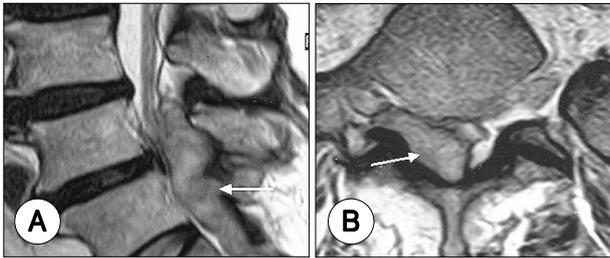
A : Preoperative sagittal T1-weighted magnetic resonance image shows a low signal intensity mass (arrows) occupying the epidural space from L4 to S1 level, B : Enhanced axial T1-weighted magnetic resonance images show rim-enhanced mass (arrows) compressing the dura in the posterior epidural space and extending into the intervertebral foramen of L4/5.
